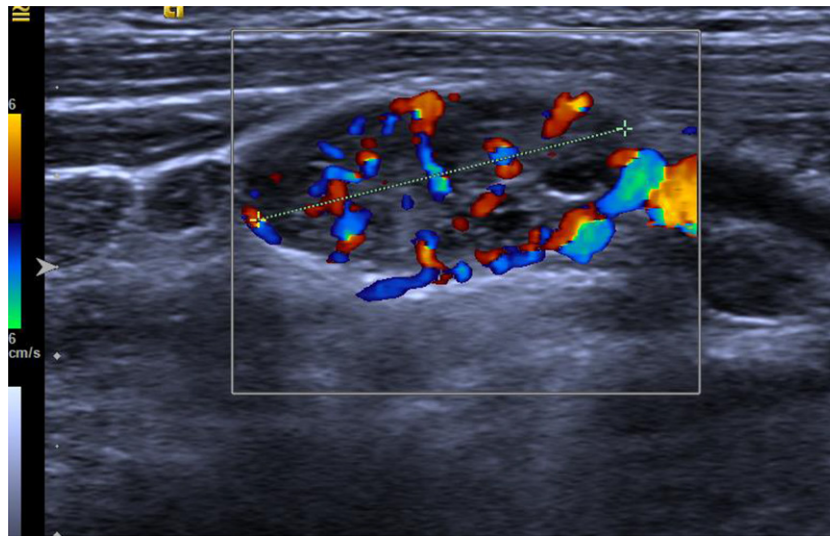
Ultrasound presentation of a neck lymph node metastasis: the node is hypoechoic with cystic areas and increased and irregular vascular signal.
